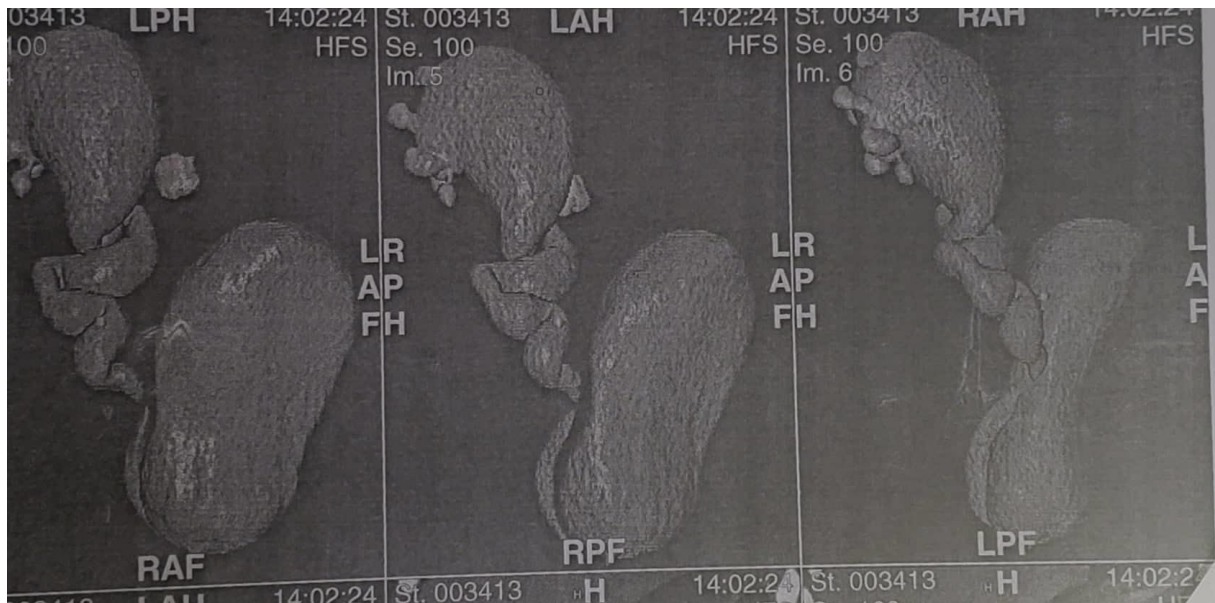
CT scan 3D reconstruction showing a right hydronephrosis with a major pyelocalicel dilation with MU in a patient in our series.
